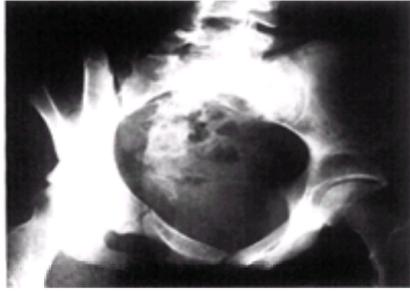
A 16-year-old girl with an isolated right pubic ramus fracture best visualized on this oblique radiographic view.
